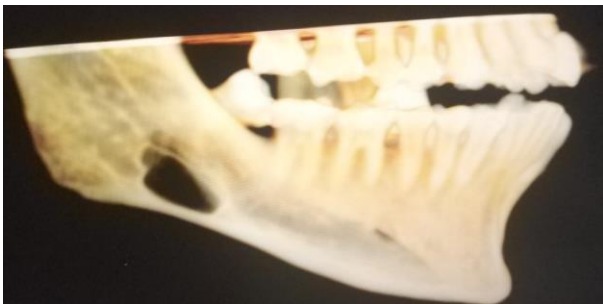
3D CBCT Showing Defect In Right Posterior Mandibular Body Ramus Region.
